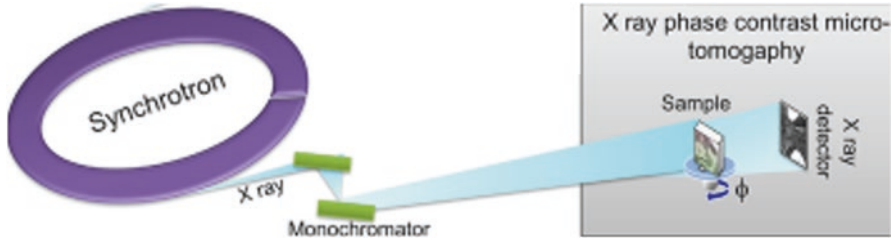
Pictorial view of the X-ray phase-contrast micro-tomography experimental approach
